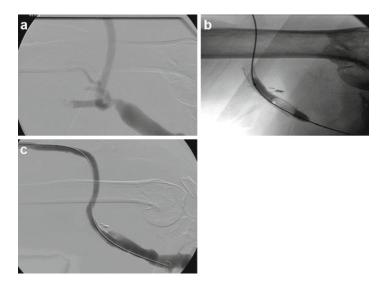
This patient is an 80-year-old woman with a brachial artery to axillary vein arteriovenous graft. She has had recurrent graft thrombosis secondary to venous anastomotic stenosis. (a) Fistulogram was performed though an 8 Fr sheath in the proximal portion of the graft, directed distally. This demonstrates persistent venous anastomotic stenosis. Balloon angioplasty using a 6 mm \times 4 cm Dorado balloon failed to improve radiographic appearance. (b) An 8 mm \times 4 cm Fluency stent graft was placed across the venous anastomosis and ballooned with an 8 mm \times 4 cm Dorado balloon. (c) Completion angiogram shows resolution of stenosis
